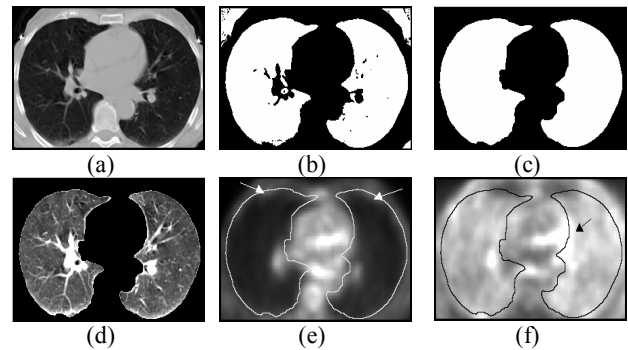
ROI segmentation steps: (a) source CT image, (b) initial thresholding of (a), (c) after closing, filling and background removal, (d) final segmentation, (e) and (f) mapping of lungs field to corrected and uncorrected PET
